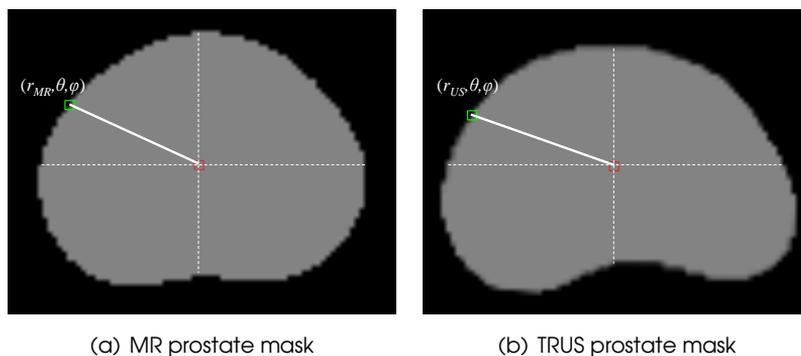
Radial surface projection to find corresponding surface points on manual prostate segmentations of MR images and TRUS images. The spherical coordinates of the surface point (green) were calculated with respect to the center of gravity (red) on the segmented MR image (a). The corresponding surface point on the TRUS image (b) has the same angular coordinates (ϕ and θ) but a different radial distance (r_{MR} and r_{US}).
